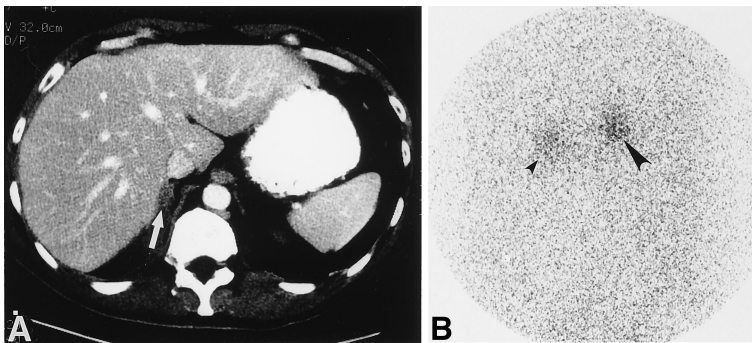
CT examination performed to stage squamous cell lung carcinoma disclosed a 1 cm diameter right adrenal mass that yielded a concordant NP59 image pattern. A. CT scan with oral and intravenous contrast demonstrates the right adrenal mass (white arrow). B. Posterior abdominal NP59 scintiscan 5 days after radiotracer injection demonstrates intense uptake in the right adrenal gland (large arrowhead) and normal NP59 uptake in the left adrenal gland (small arrowhead). The lesion remained stable on follow-up CT examinations despite progression of the primary tumor and development of distant nonadrenal metastases.
